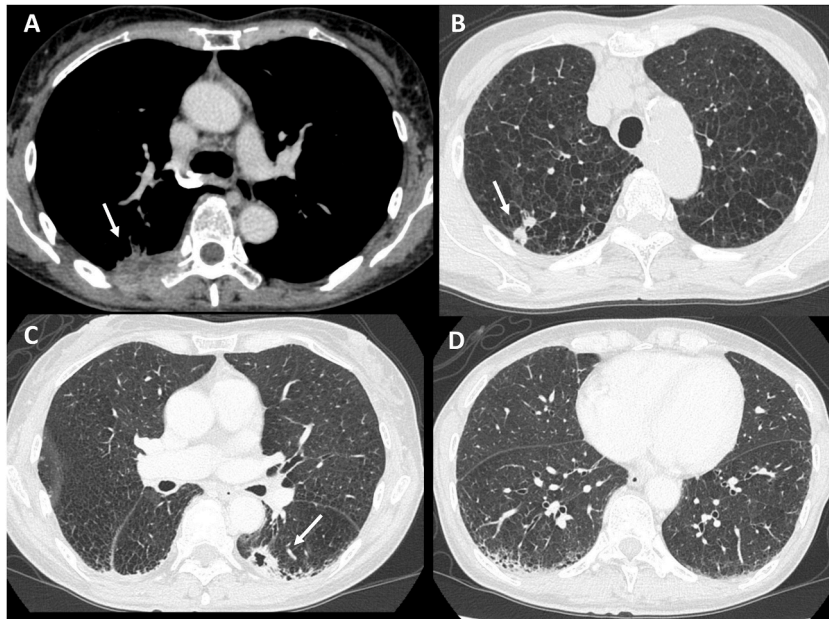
A: Contrast-enhanced computed tomography of the chest (soft-tissue windows), showing partially enhanced subpleural nodular consolidation (40 mm in diameter) invading the chest wall. B: Computed tomography of the chest (lung windows) showing two nodules (6 mm and 8 mm in diameter, respectively) in the right upper lobe. C: Computed tomography of the chest (lung windows) showing a cavitary nodule (21mm in diameter) in the left lower lobe. D: Computed tomography of the chest (lung windows) showing reticulonodular shadows in the periphery of bilateral lower lobes, suggesting the interstitial pneumonia.
